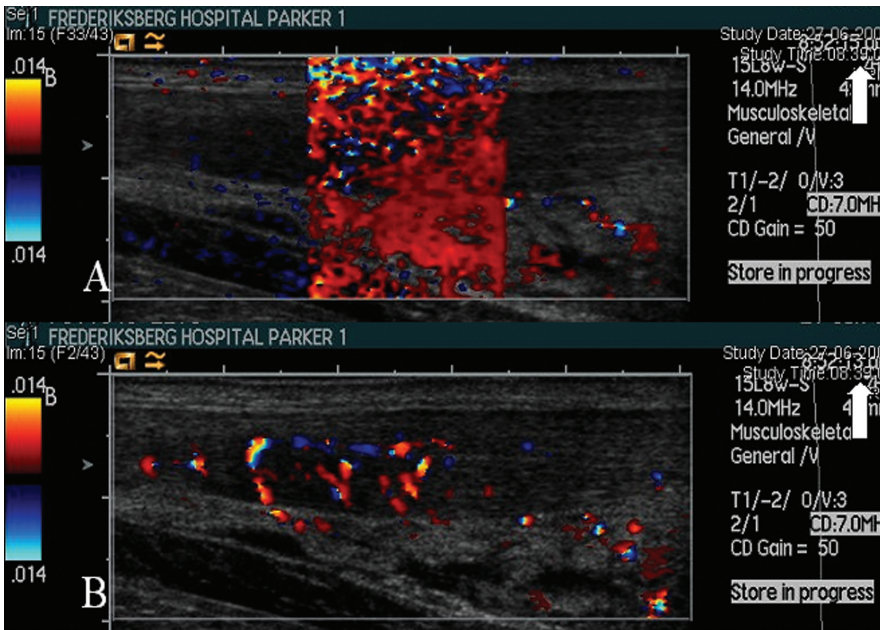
Motion artefact. Movement of the patient or the examiner during Doppler imaging gives a motion relative to the transducer and produces a Doppler shift, which appears as random short flashes of large confluent areas of colour (A). The same examination without the motion artefact is seen in (B). The clock (arrows at the top right corner) shows that the two images are from within the same second.
